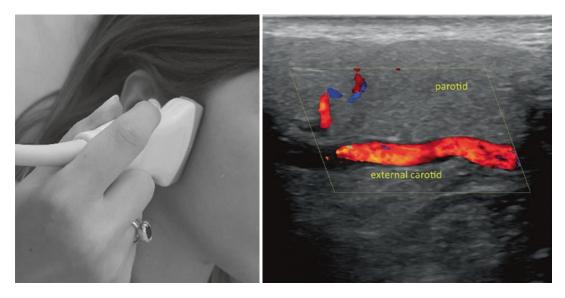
Presence of a color signal in the intraparotid part of the external carotid artery during Doppler control. Each parotid should be evaluated for both transverse and sagittal scans
